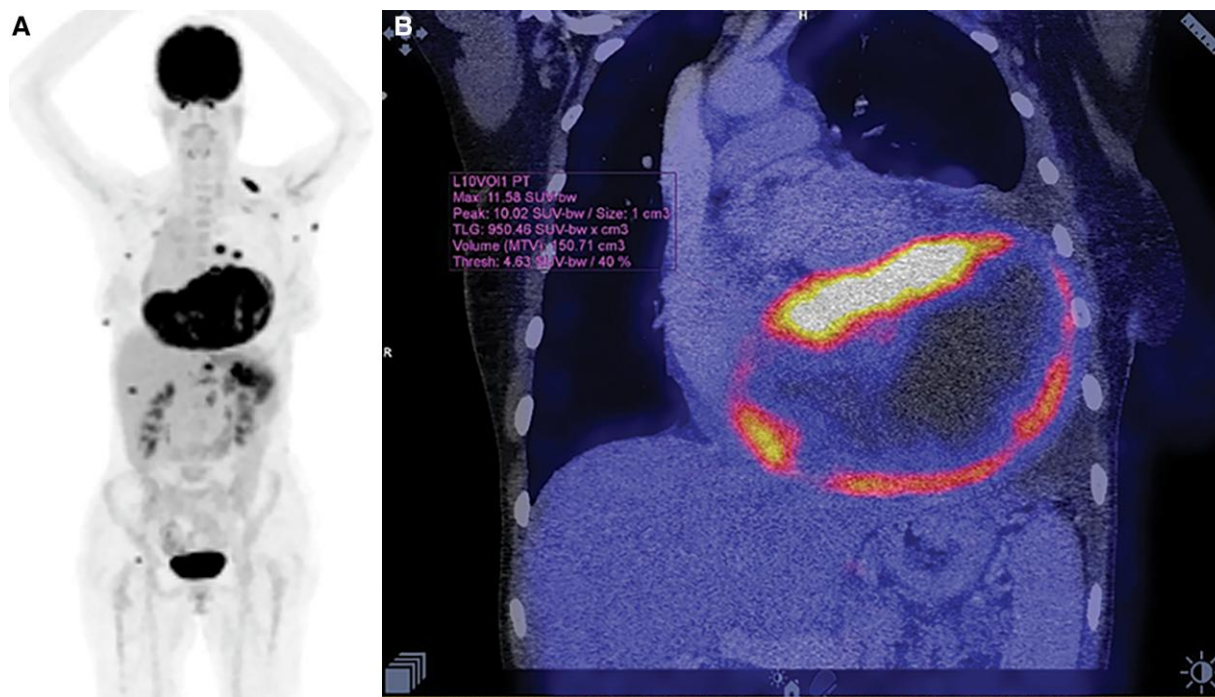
(A) Baseline whole-body positron emission tomography. (B) Baseline fused positron emission tomography/computed tomography image demonstrating the cardiac metastasis in the coronal plane.
